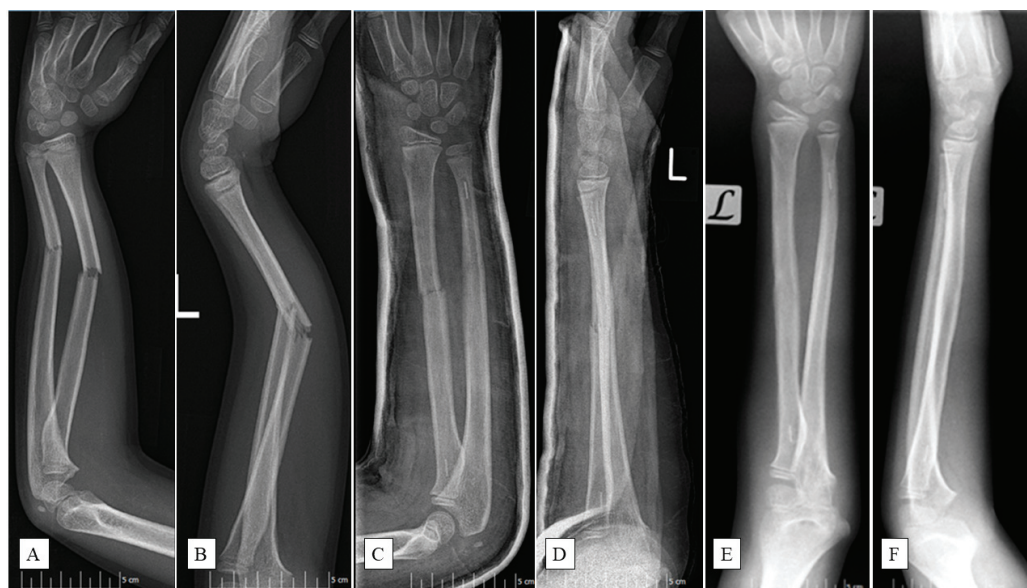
An 11-year-old boy fell while playing football and had a deformed left (L) arm. Preoperative anteroposterior (AP) (A) and lateral (B) radiographic views of the forearm exposed subperiosteal fractures of both ulna and radius. X-rays post-surgery ((C)—AP, (D)—lateral aspects) show the successful insertion of PLGA implants, confirmed by the radiopaque markers. Six-month control images ((E)—AP, (F)—lateral views) revealed completely healed fractures with good axial alignment.
